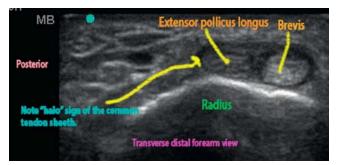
De Quervain's tenosynovitis. Transverse ultrasound image of the first dorsal compartment tendons (abductor pollicis longus and extensor pollicis brevis) showing tenosynovitis. Note the halo sign around tendons due to fluid surrounding the inflamed tendons.
